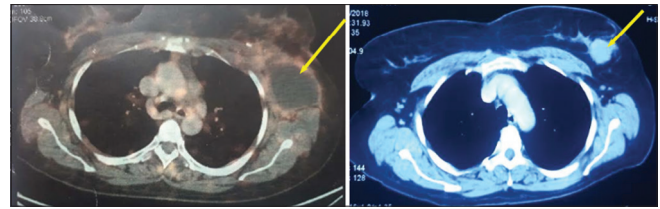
Positron emission tomography-computed tomography showing heterogeneously enhancing soft-tissue nodule in upper outer quadrant of the left breast (arrowhead)
